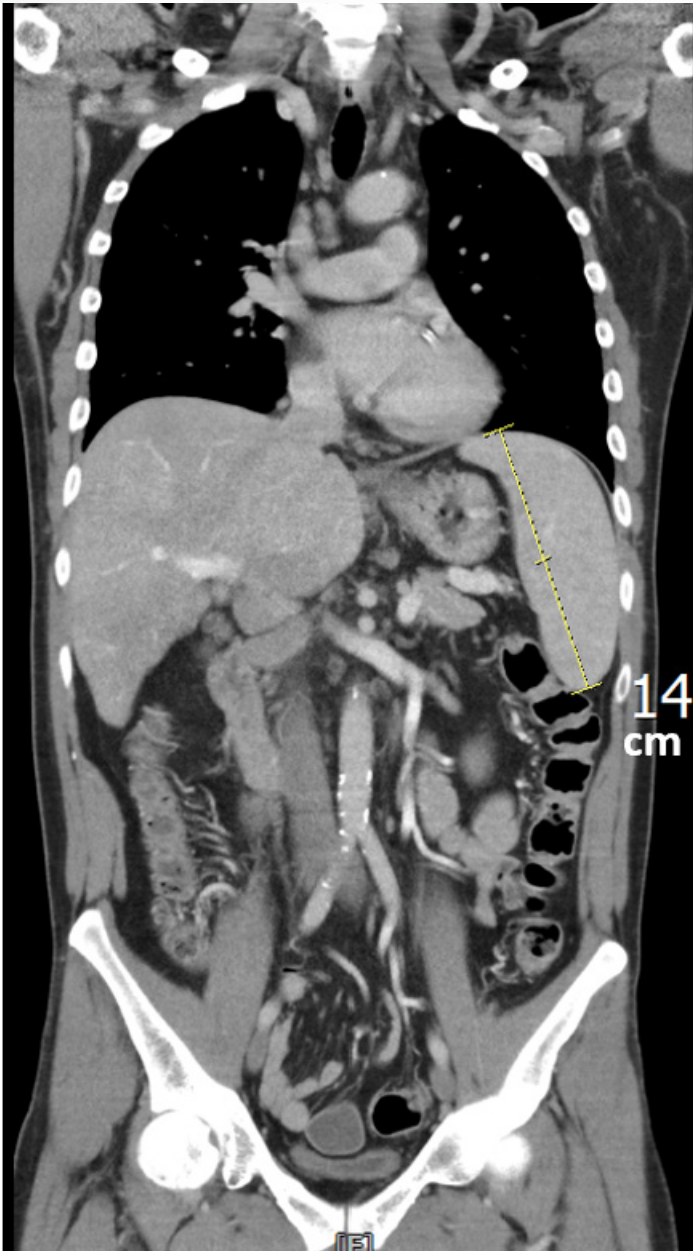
CT showed liver nodules and splenomegaly (diameter 14 cm).
